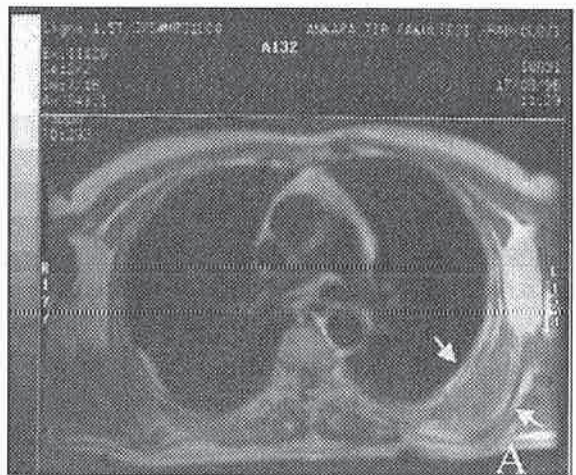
On T1-weighted axial image, a 8x3x3 cm soft tissue mass, inferior to left serratus anterior muscle, low to intermediate in signal intensity relative to the skeletal muscles with intervening
